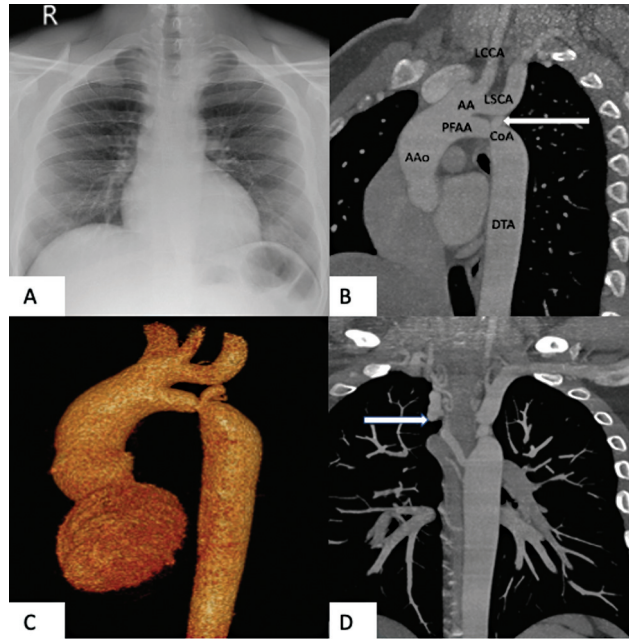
(A) Chest radiograph at the time of presentation reveals normal cardiac silhouette and lung fields. (B) Computed tomography (CT) maximum intensity projection in the sagittal oblique plane shows the single vessel from ascending aorta giving rise to the head and neck vessels, while the lower lumen with no branching represents the persistent fifth aortic arch (PFAA). Also shown is the coarctation of distal PFAA with adjacent saccular outpouching (white arrow) better visualized in Volume reconstructed images (C). There are multiple intercostal collaterals suggestive of significant coarctation (D). Aao, ascending aorta; AA, aortic arch; CoA, coarctation of aorta; DTA, descending aorta; LCCA, left common carotid artery; LSCA, left subclavian artery. Three-dimensional reconstruction (B) from the CT angiography showing similar findings.
